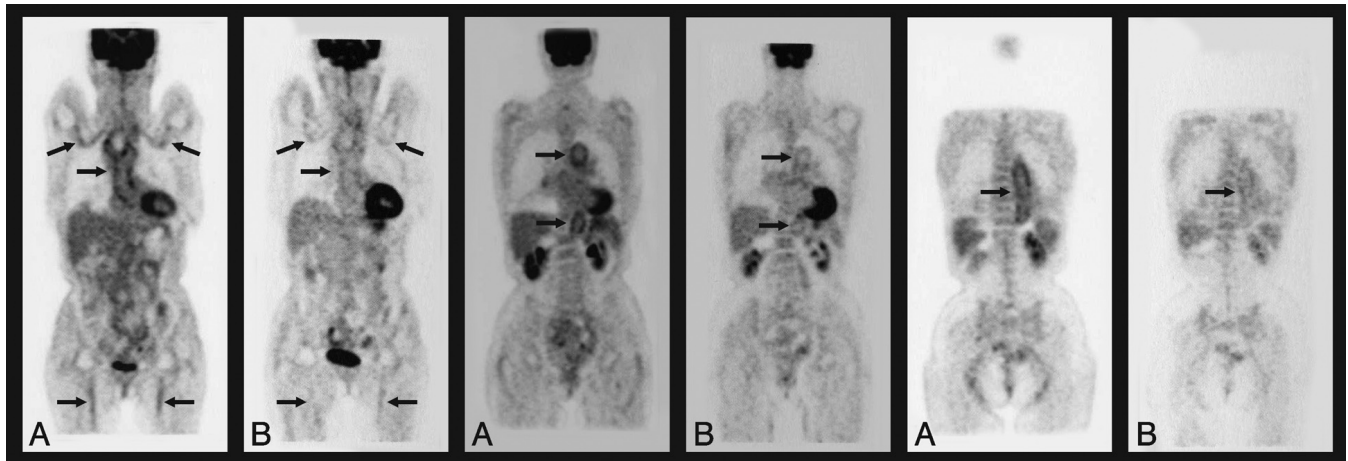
PET-CT uptake of (18F) fluorodeoxyglucose in the large vessels (arrows) of a patient with polymyalgia rheumatica and vasculitis before (A) and after (B) the addition of methotrexate to the standard steroid treatment.
